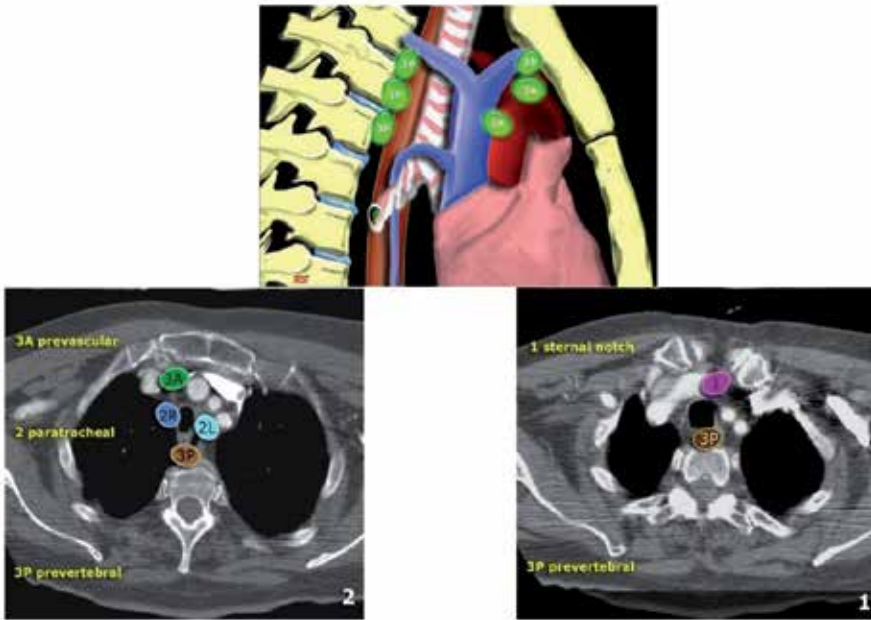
Prevascular and Prevertebral nodes. Station 3 nodes are not adjacent to the trachea like station 2 nodes. They are either: 3A anterior to the vessels or 3P behind the esophagus, which lies prevertebrally. Station 3 nodes are not accessible with mediastinoscopy. 3P nodes can be accessible with endoscopic ultrasound (EUS) [111].
